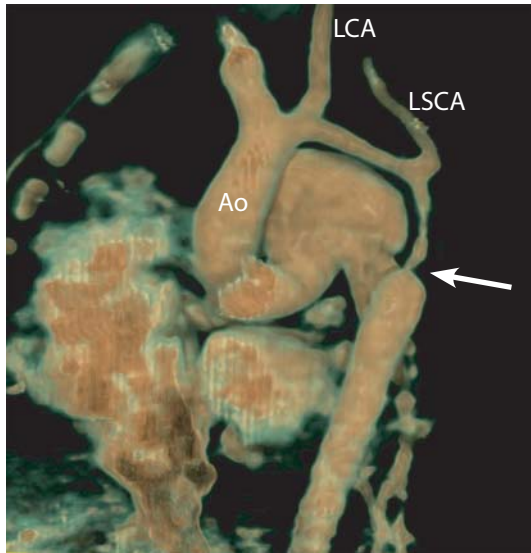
Aortic coarctation in a 1-month-old baby examined with 16-slice CT. Total interruption of aortic arch was suspected from echocardiography. The 16-slice CT showed long stenosis of the aorta with post-ductal severe narrowing (*arrow*). *LCA* Left carotid artery, *LSCA* left subclavian artery
